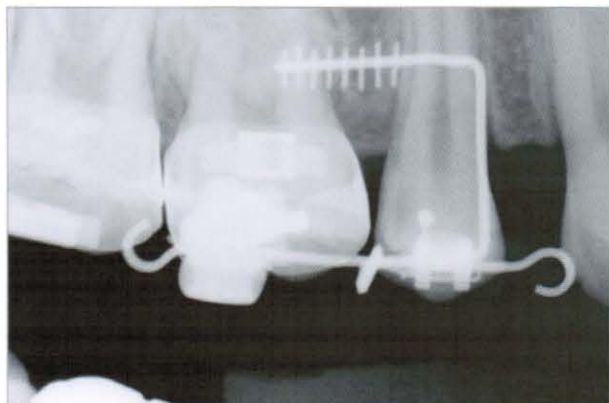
Periapical radiograph with Kim's stent in place. In an ideal situation, the contact point between the second premolar and first molar is clearly seen and the proximal surfaces of adjacent teeth do not overlap.
